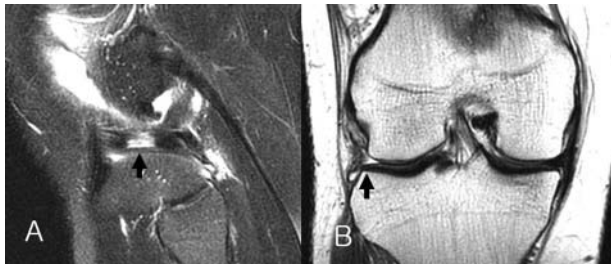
A, sagittal MRI view demonstrating a radial tear (arrow) of the midbody of the lateral meniscus in a 19-year-old patient. B, coronal MRI view demonstrating absent midbody of the lateral meniscus due to radial tear (arrow).
